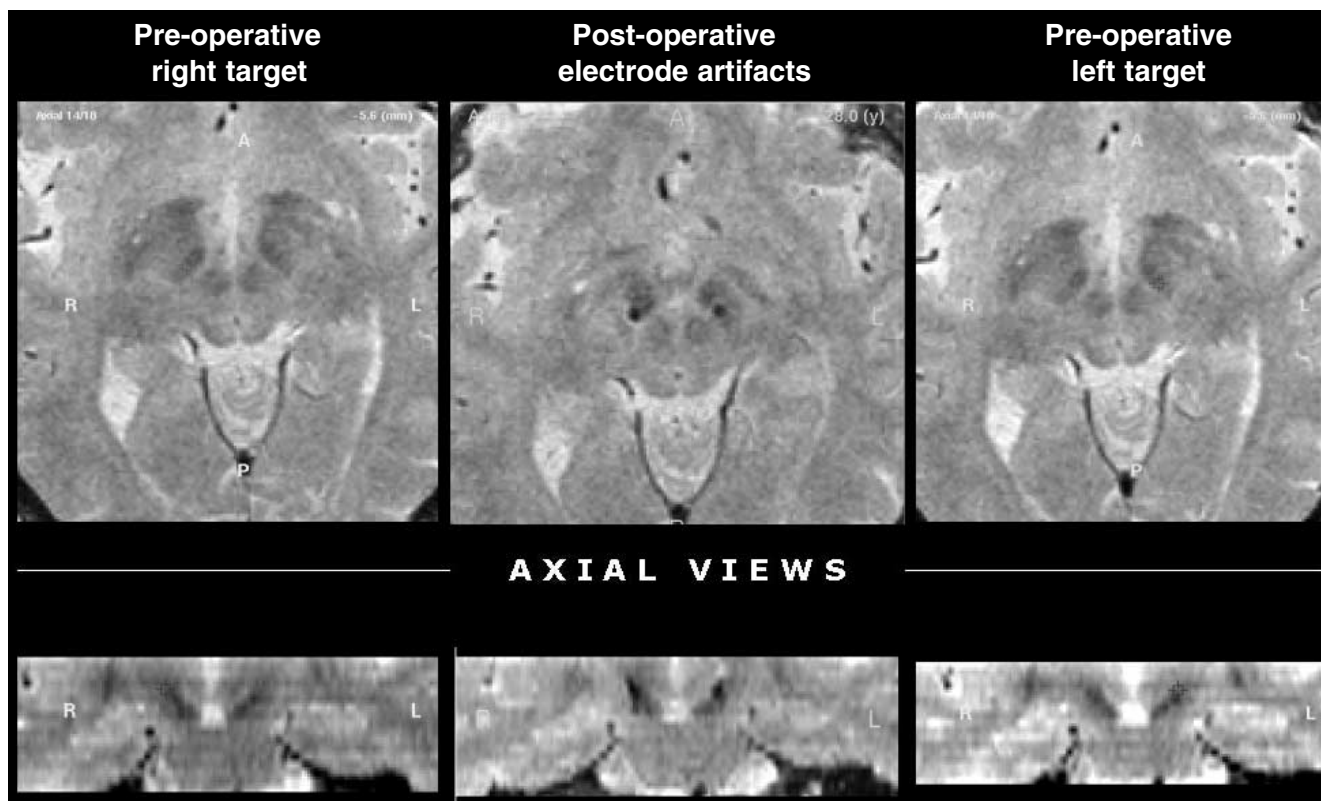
T2 MR images of the pre-operative planned targets and postoperative artifacts of the implanted electrodes in the STN target
